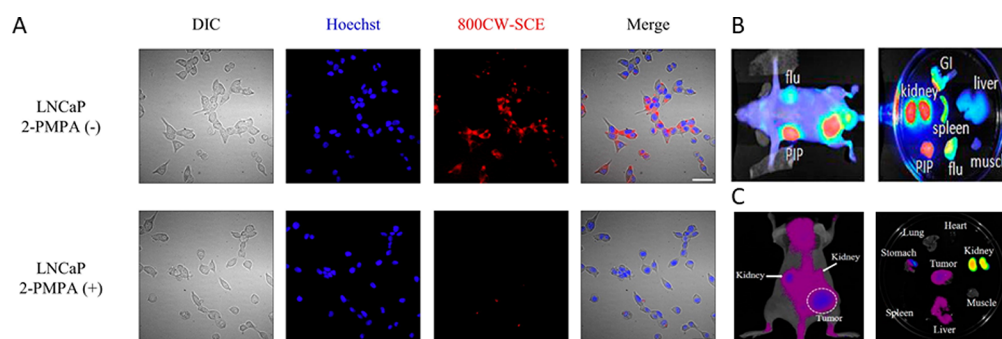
(A) In vitro uptake of IRDye800CW-SCE in PSMA-positive LNCaP cells (top) with blocking by 2-PMPA (bottom) (adapted from Matusoka et al.¹⁰⁴ with permission from Elsevier). Example of in vivo imaging and typical biodistribution for (B) IRDye800CW-1 (adapted from Chen et al.)¹⁰¹ and (C) Cy5.5(SO₃⁻)₄-EuK (adapted from Kwon et al.)¹⁰³
